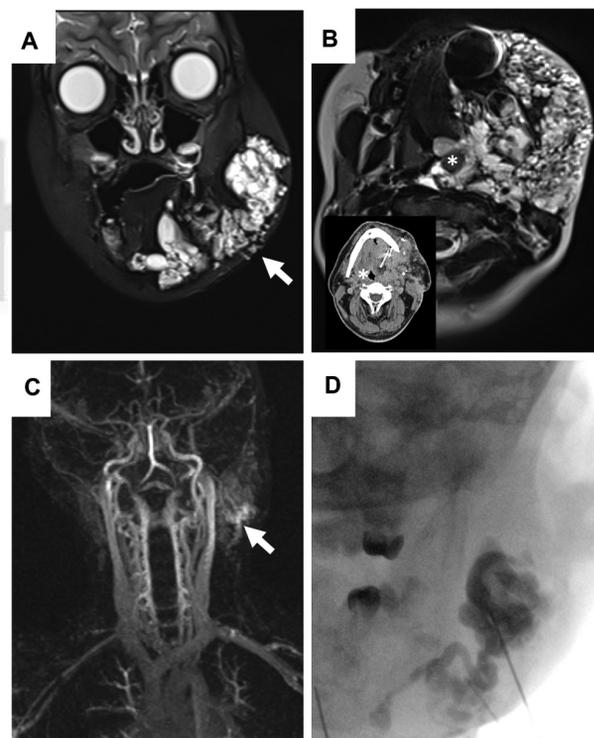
Venous malformation of the face and neck in a 1-year-old girl. (A) MR images of an extensive venous malformation. Coronal view demonstrates T2 hyperintense dysplastic venous cavities, beginning in the subcutaneous fat (arrow) infiltrating the masseter muscle and deeper tissues. (B) Transverse images reveal infiltration of all tissue layers extending into the paratracheal structures, imposing a high risk for tracheal stenosis (asterisk) or occlusion in case of volume increase of the lesion; lower left image shows CT-guided puncture of paratracheal malformation for sclerotherapy. (C) Dynamic MR angiography reveals only late filling of the malformation (arrow), corresponding to the slow-flow situation. (D) Fluoroscopy following percutaneous puncture and contrast injection reveals communicating dysplastic venous channels, infiltration of all tissue layers of the face and neck.
